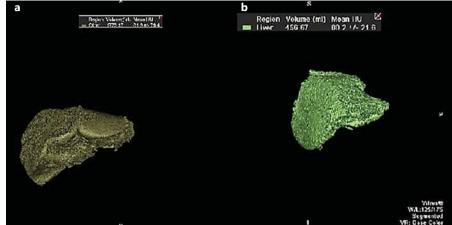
a, b Volumetry for operative planning. CT-based volumetry can assess the FLR volume following extended right hepatectomy. This technique may be used preand post-PVE to assess the hypertrophic response to embolisation. The whole liver is seen on the left, and on the right the volume of segments 2 and 3 are shown in green.
